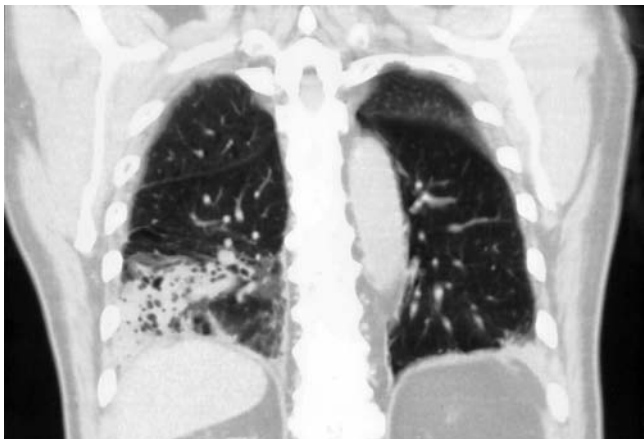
Coronal section CT scan of chest showing consolidation of right lobe extending to the pleura.
